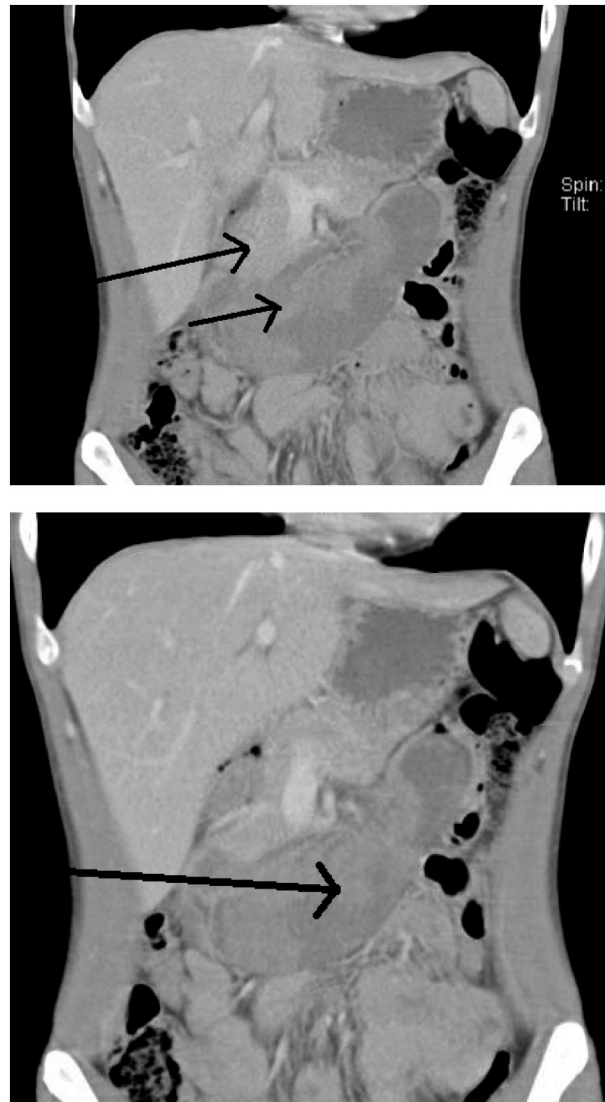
Contrast enhanced CT Coronal view image demonstrating the extent of hematoma.
